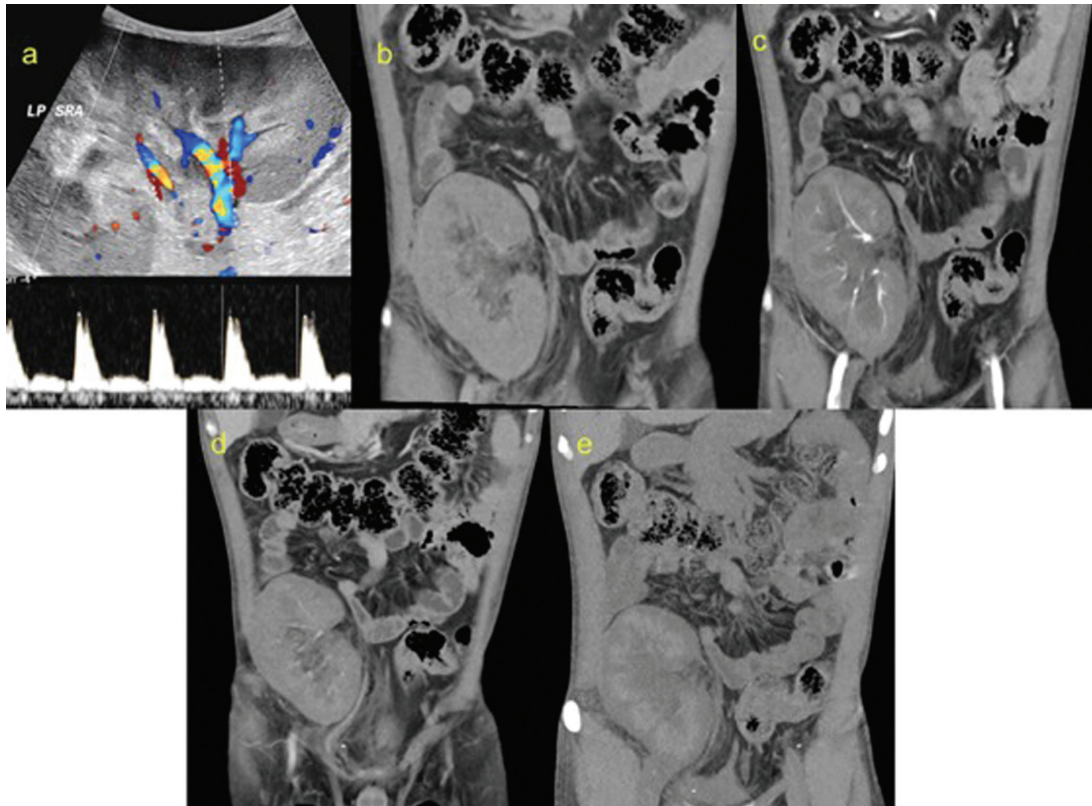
Ultrasound image (a) shows enlarged transplant kidney with increased cortical echogenicity and increased RI on spectral doppler. CT images in coronal plane in plain (b), arterial (c), venous (d), and delayed (e) phases show transplant kidney in RIF with diffuse poor enhancement of renal parenchyma suggesting diffuse renal parenchymal disease. The parenchymal changes in this patient was attributed to drug toxicity. CI, confidence interval; CT, computed tomography; RI, resistivity index; RIF, renal interstitial fibrosis.
